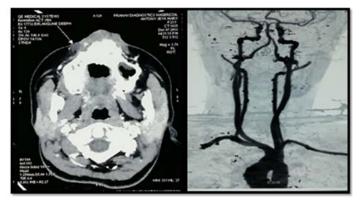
CT Neck Angiography reveals a large expansile bony lesion in the left maxilla involving the alveolar process and adjacent hard palate.
